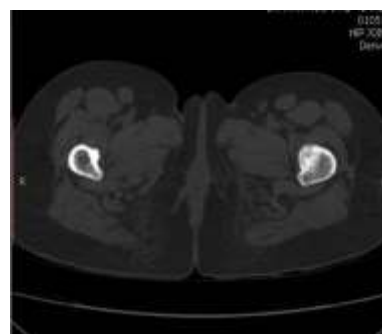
Follow-up CT after 1 month show mild sclerosis of the nidus.
